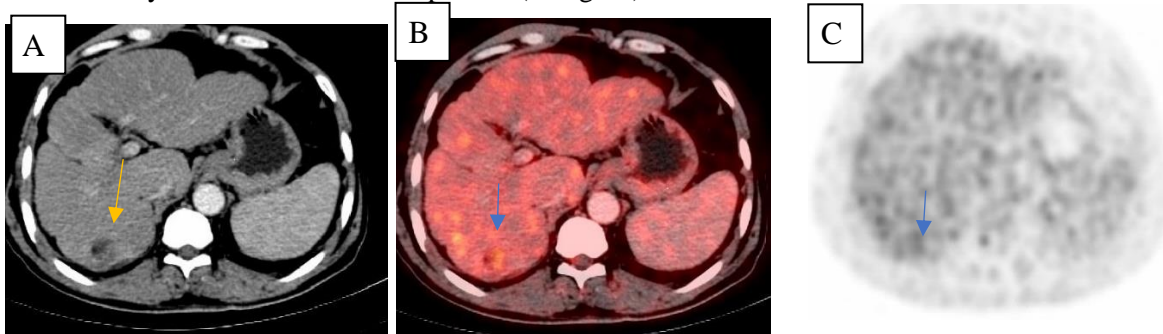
(A) Male patient aged 53 years, diagnosed hepatocellular carcinoma, complaining of abdominal pain 3 months ago underwent radiofrequency ablation 5 weeks ago. (A, B & C) Axial CT, PET/CT & PET images show right hepatic lobe segment VII hypodense focal lesion shows heterogenously peripheral enhancement at contrast enhanced CT (yellow arrow) with peripheral increased metabolic activity of the same lesion (blue arrow) showing low peripheral FGD uptake with SUV max 3.4 at PET/CT images denoting residual tumoral activity.
